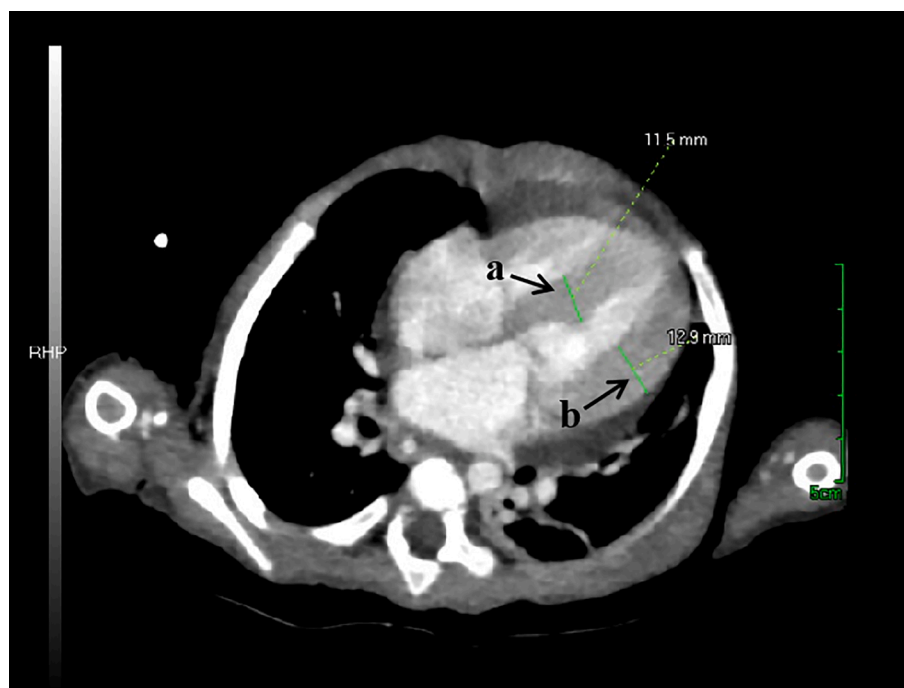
The cardiac CT of the patient showed the thickness of the interventricular septum to be approximately 11.5 mm (a) and the thickness of the posterior wall of the left ventricle to be approximately 12.9 mm (b).
